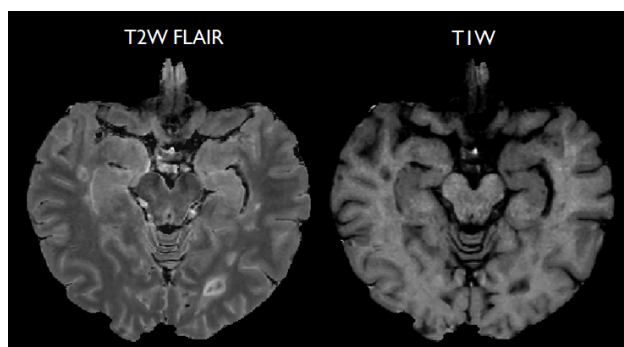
T2W FLAIR and T1W generated by SyMRI
